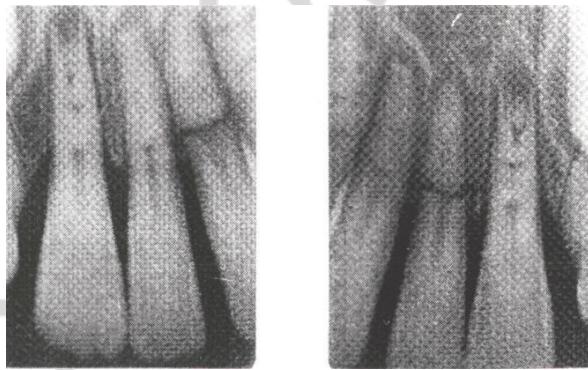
Radicular dentin dysplasia, X-ray picture:
